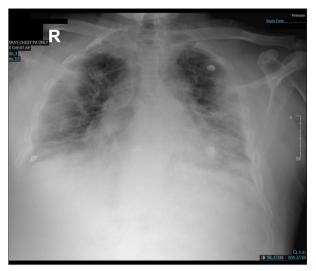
Confirmed case of COVID-19 in a 41-year-old man with an anterior-posterior chest X-ray showing diffuse bilateral patchy infiltrate.
